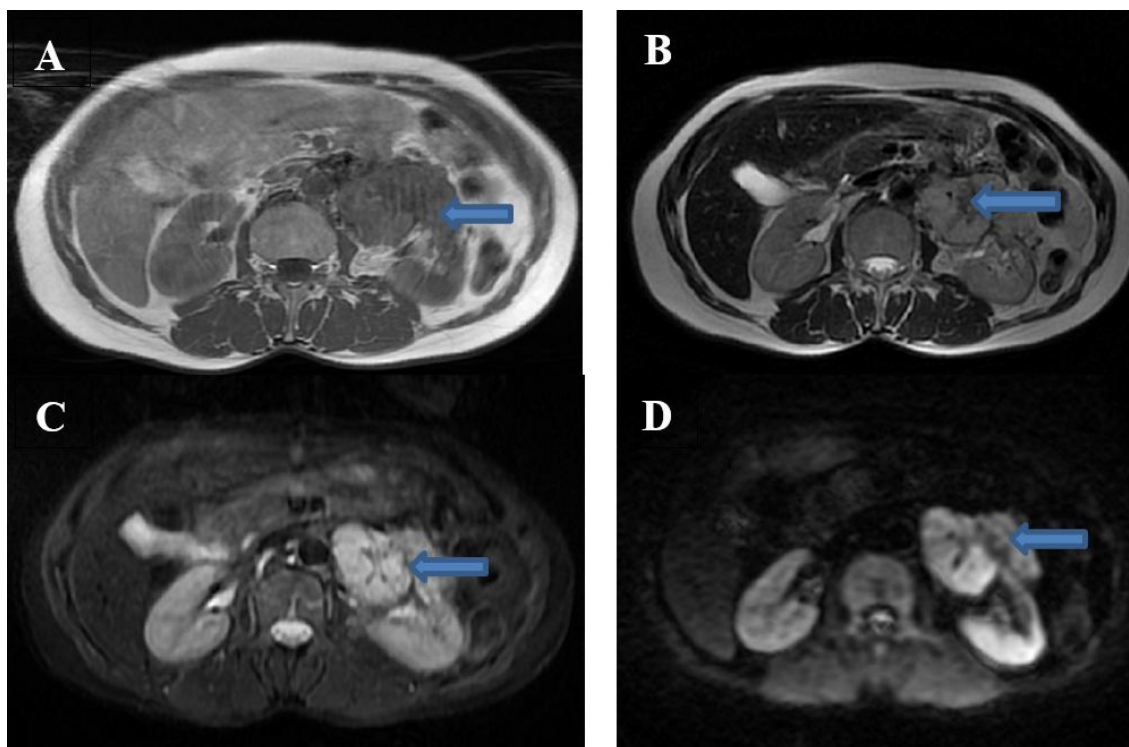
(A) Axial renal MRI (T1 sequence with contrast) shows left renal isointense mass, (B) Axial renal MRI (T2 sequence) shows left renal isointense mass, (C) Axial renal MRI (DWI sequence) shows restricted diffusion, (D) Axial renal MRI (ADC) shows high signal. Patient underwent nephrectomy and pathology revealed diagnosis as left renal oncocytoma
